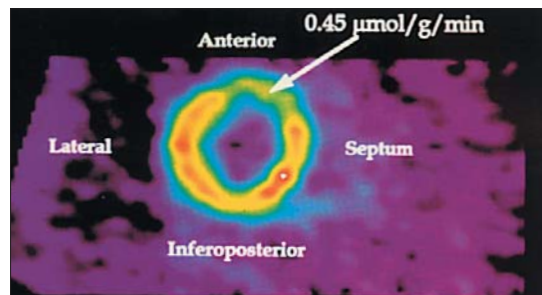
FDG scan from a patient with viable hibernating myocardium.
